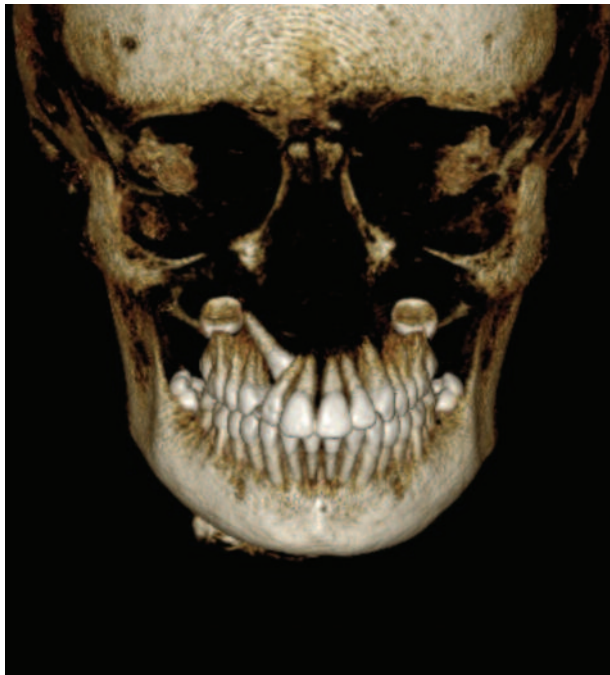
A 3D reconstructed color image reveals the “true” position of the impacted cuspid. This image and related CBCT images allow for improved surgical planning in comparison to standard digital images.
